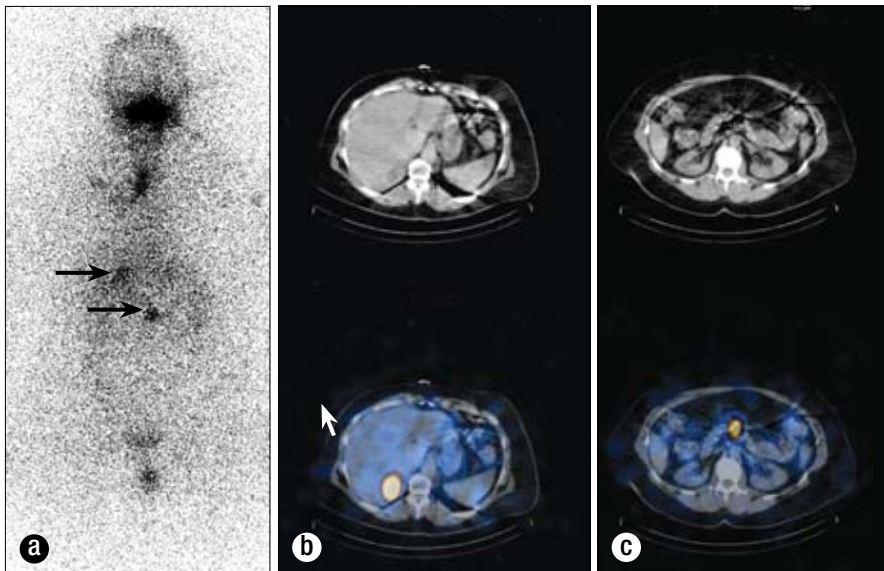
Whole-body I-131 scintigraphy study of October 13, 2009. (a) The anterior image demonstrates a region of intense increased radiotracer accumulation in the right upper quadrant, projecting over the liver (arrow). A second region of moderate increased radiotracer accumulation is located within the midabdomen, located slightly inferior to the previously described right upper quadrant activity (arrow). The vertical increased radiotracer accumulation at the neck was confirmed to reflect activity at the patient's tracheostomy site on single photon emission computed tomography (SPECT) consistent with inflammatory-type tracer uptake. Physiologic tracer accumulation was also identified in the mouth and urinary bladder. (b) Fusion images through the liver demonstrate that the round region of increased I-131 tracer accumulation corresponds to a low-density right hepatic lobe lesion on CT localization images. (c) Images through the midabdomen demonstrate a region of increased I-131 tracer accumulation located at the level of the inferior pancreas, without a definite correlate on CT localization images.
